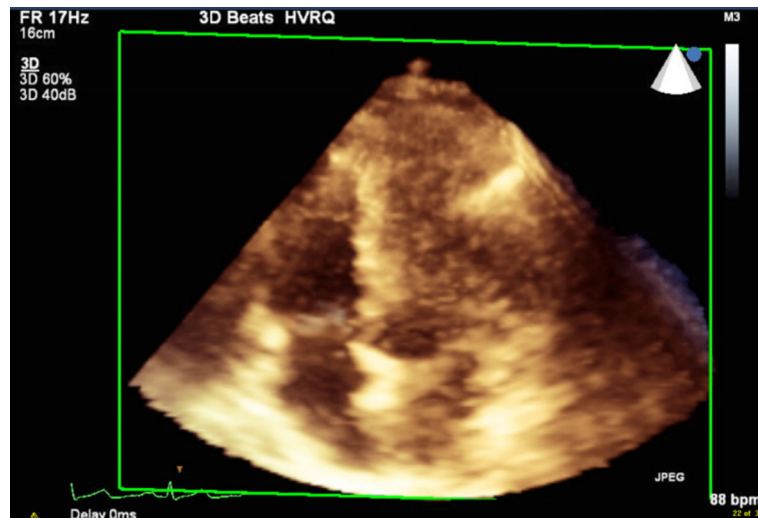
Transthoracic 3D image of the right ventricle in apical four chamber view
